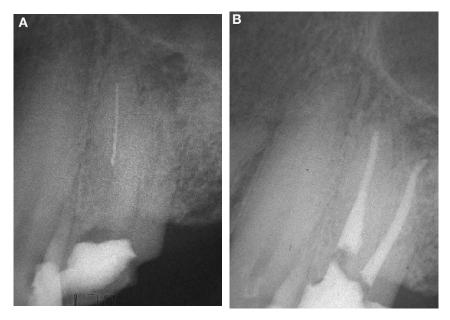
(A) Preoperative radiograph of a maxillary left first premolar shows a separated instrument in the palatal canal. (B) Postobturation radiograph. The instrument was removed easily with ultrasonic vibration. (Courtesy of Dr. Bekir Karabucak, Philadelphia, PA.)
